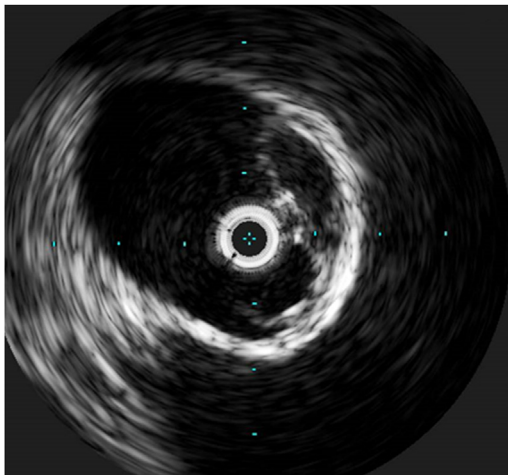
Intravascular ultrasound of patient 2 showing a double barrel fibrin sheath after decannulation.
